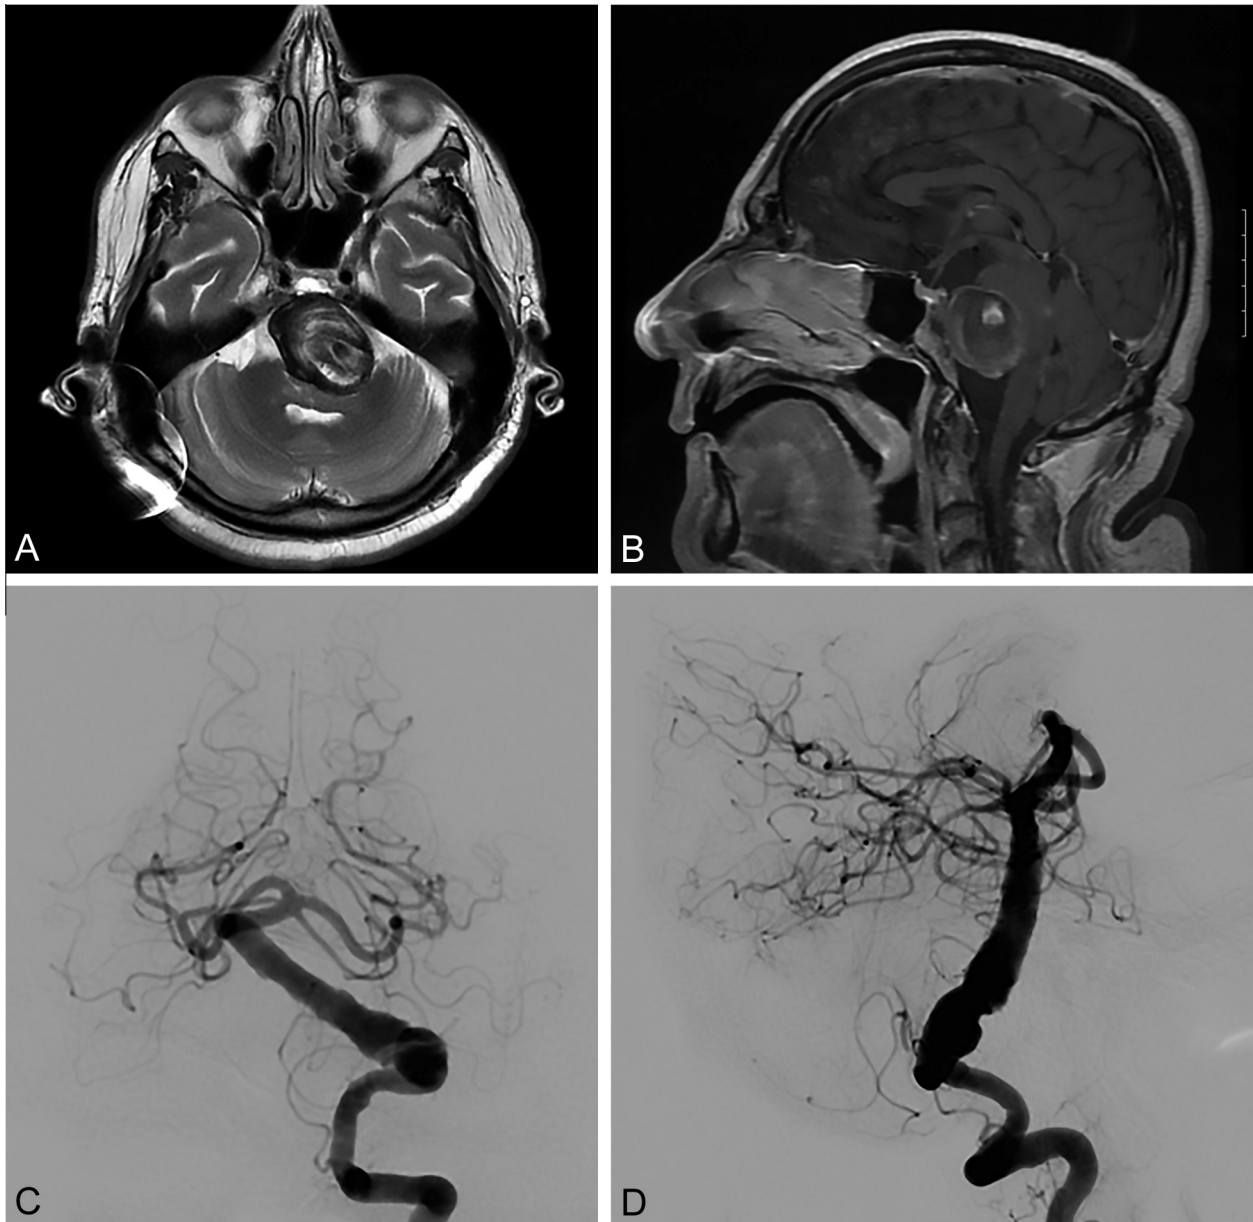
(A) Axial T2-weighted and (B) sagittal T1-weighted MRI scans reveal a giant partially thrombosed aneurysm. (C) Townes and (D) lateral angiographic views reveal the dysplastic nature of the aneurysm. *Used with permission of Barrow Neurological Institute, Phoenix, Arizona.*
